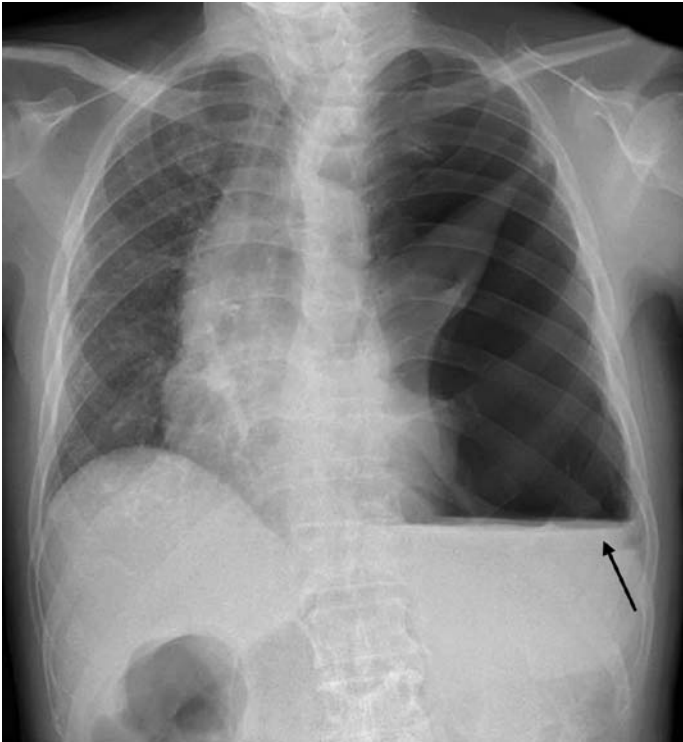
Chest X-ray for hemopneumothorax blood/fluid level (arrow)
